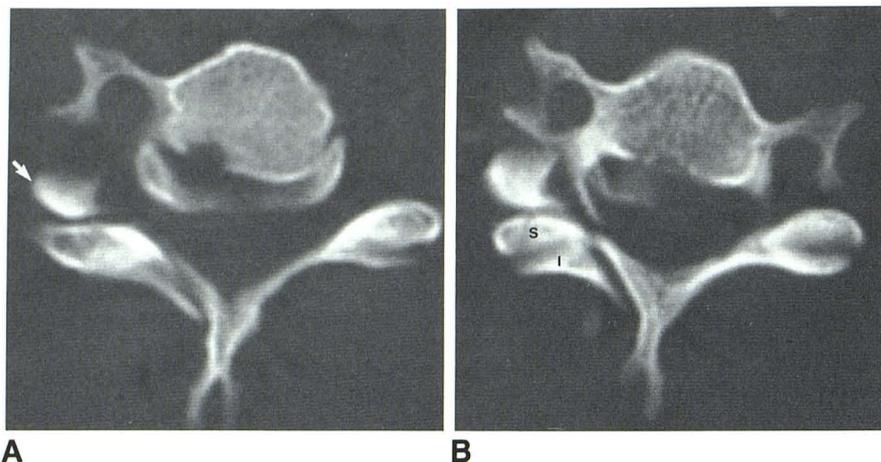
Comminuted right articular pillar fracture. CT scans. Fracture fragment (A, arrow) in front of facet joint suggests locked facet. Fragments and articular processes (S, I) are shown better in slightly higher cut (B).
